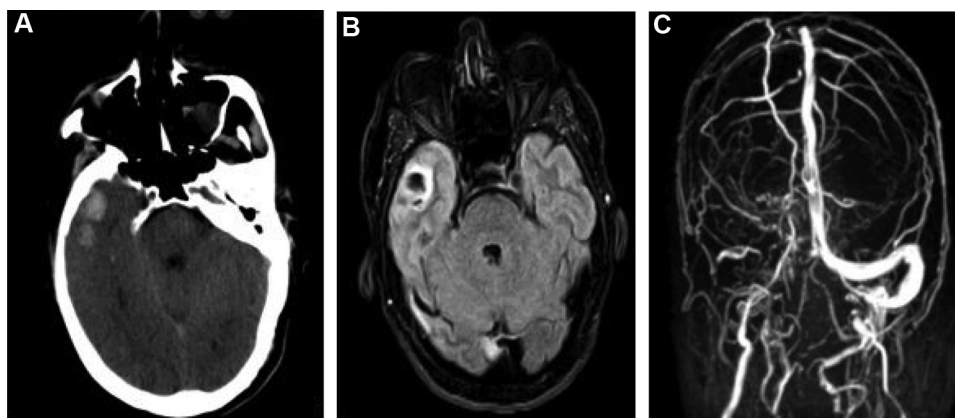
A.computed tomography (CT) image showed hemorrhage in right temporal lobe B. Fluid-attenuated inversion recovery images showed hemorrhagic infarct. C. Magnetic resonance venography demonstrates right sigmoid and transverse sinus thrombosis.
